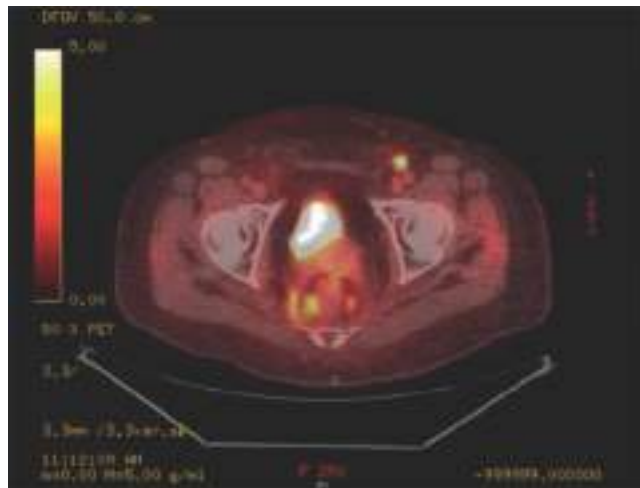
Anal cancer: left inguinal adenopathy and mesorectal adenopathy seen on PET/CT.
